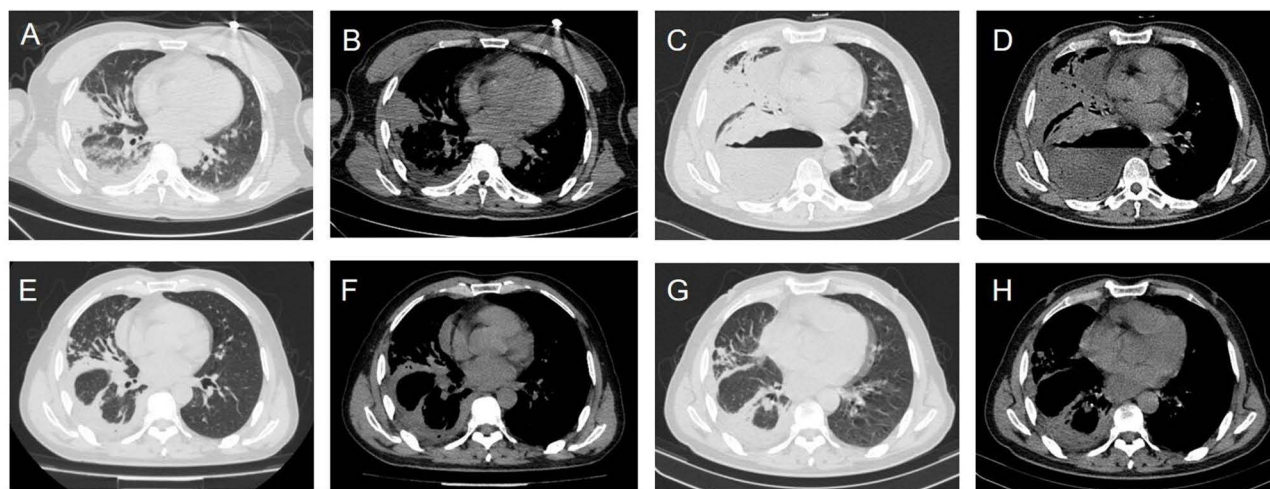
Chest CT imaging of a 55-year-old male with pyopneumothorax caused by *Fusobacterium nucleatum*: 1) Day 1: Pneumonia with right pleural thickening and pleural effusion (A and B); 2) Day 8: Worsening pneumonia with enlargement of right-sided encapsulated fluid pneumothorax (C and D); 3) Day 16: Improvement of right-sided liquid pneumothorax with reduced inflammation (E and F); 4) Day 24: Resolution following appropriate antibiotic treatment (G and H).
